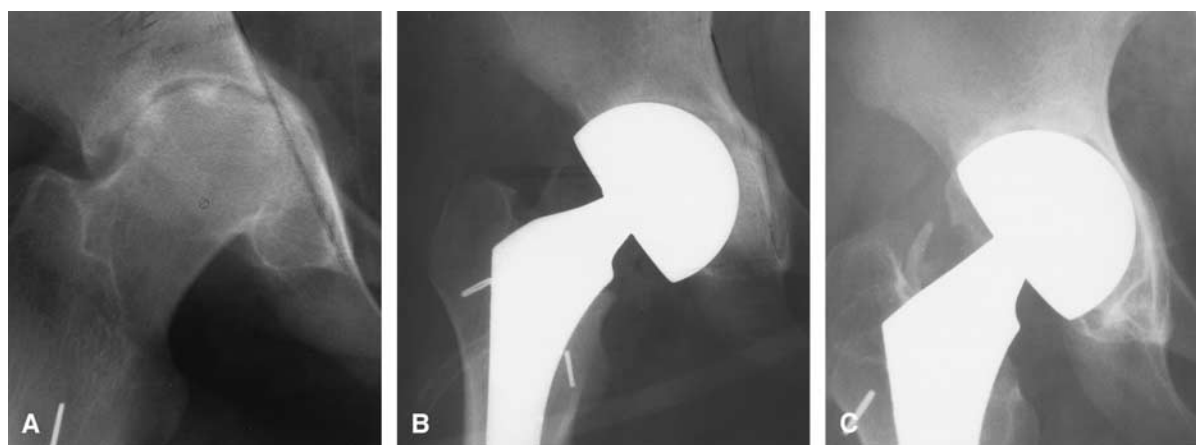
(A) Preoperative radiograph shows degenerative changes with protrusion. (B) Early postoperative acetabular reconstruction with bone-graft. Note graft incorporation and correction of hip center. (C) Follow-up radiograph shows recurrent superomedial migration.
